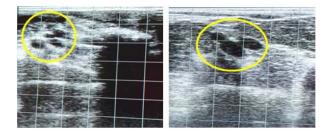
Ultrasonographic images of the ewes' ovaries obtained using a transrectal 7.5 MHz linear array probe displayed using a real-time B-mode ultrasonography
